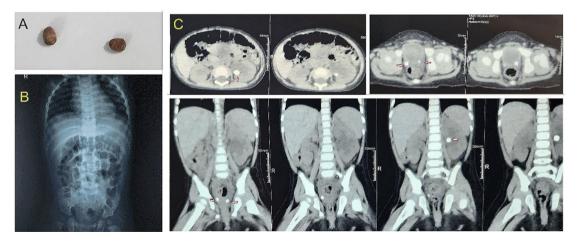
A. Two tiny calculi passed spontaneously. B. X-ray of the KUB region showing no evidence of any radio-opaque shadow. C. Axial and coronal CT images showing the 10 mm (427 HU) non obstructive calculus in left renal Pelvis, a 6.5 mm (402 HU) right distal ureter calculus, 6mm calculus (352 HU) at left UVJ (Calculi are Indicated by red arrows)
